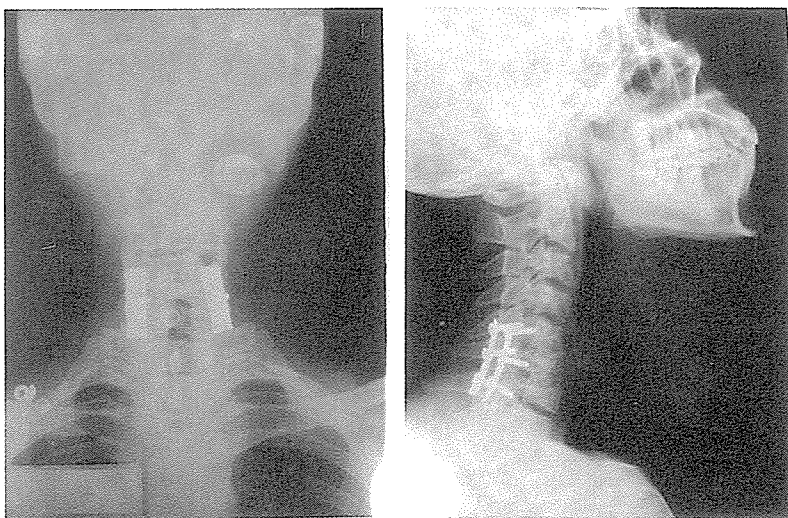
Early postoperative anteroposterior and lateral X-rays of the case in Fig-2 after combined fusion and double plate-screw fixation.
